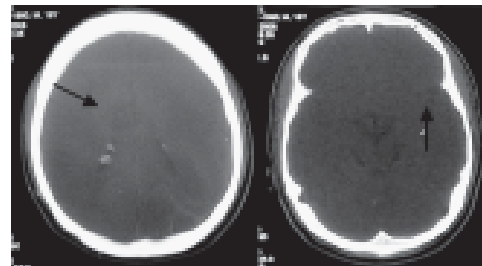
CT scan (bony window) of head confirmed the presence of calcifications (arrows).
